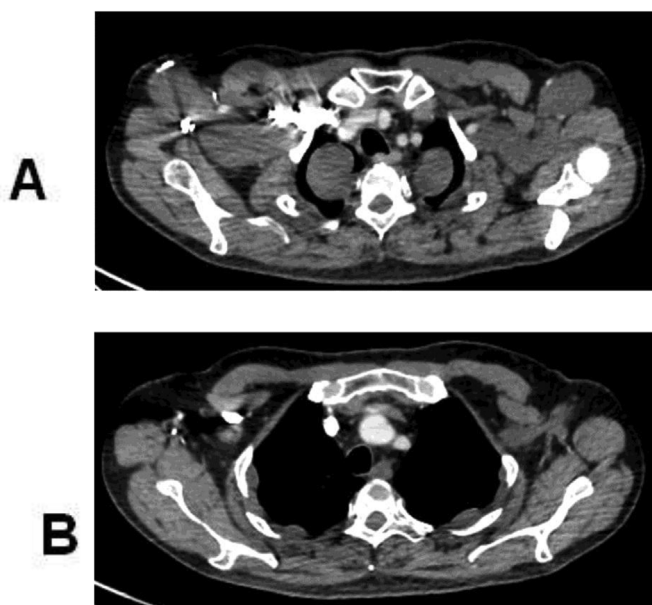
A 56-year-old man with neurofibromatosis type 1. Contrast-enhanced axial (a and b) high-resolution chest CT images obtained with mediastinal window settings demonstrate multiple hypodense, well-delimited round masses in the intercostal spaces, protruding to both lungs. These masses did not enhance with contrast and were ultimately diagnosed as neurofibromas. Other similar lesions are visible in the deep axillary region.
